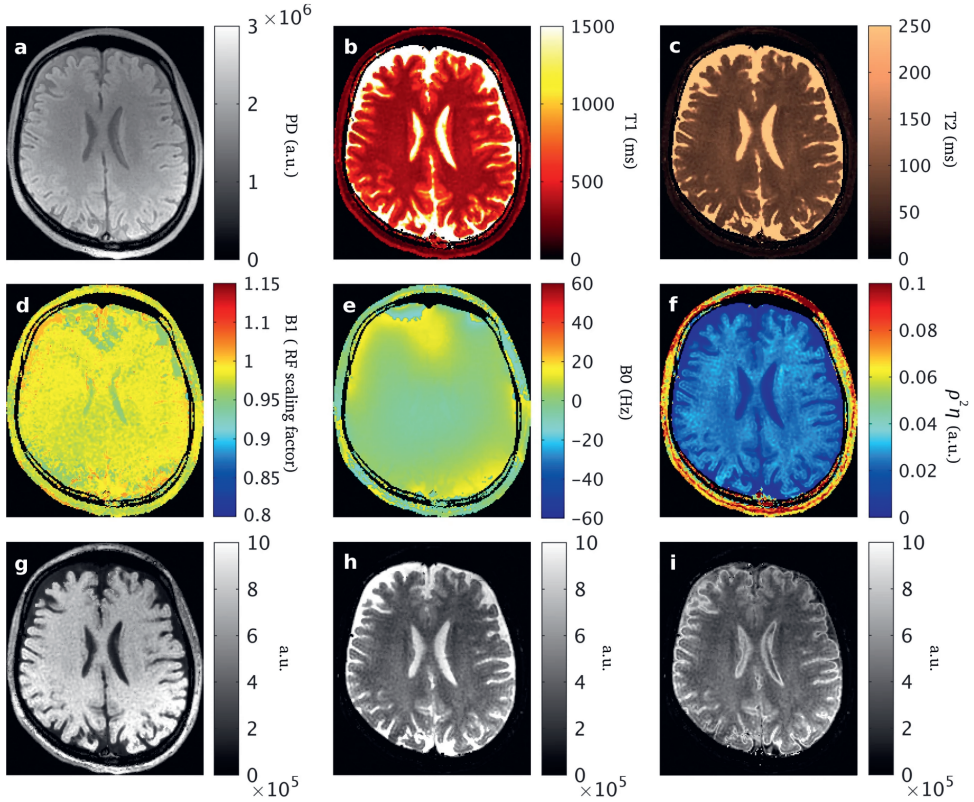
The parametric maps derived with the proposed model are shown estimated from the MP-b-nSSFP sequence with  $\alpha = 30^\circ$ ,  $\gamma = 175^\circ$ ,  $TR=30$  ms. Top row shows: (a) PD (proton density, a.u.); (b) T1(ms); (c) T2 (ms); (d) B+1 (excitation RF field scaling factor); (e)B0 (deviation in static magnetic field; Hz); (f)  $\rho^2\eta = \det(A) = \epsilon_2^2\epsilon_1$  (HO harmonic oscillator), (g) synthetic T1-weighted; (h) synthetic T2-weighted; (i) synthetic T2-FLAIR.
